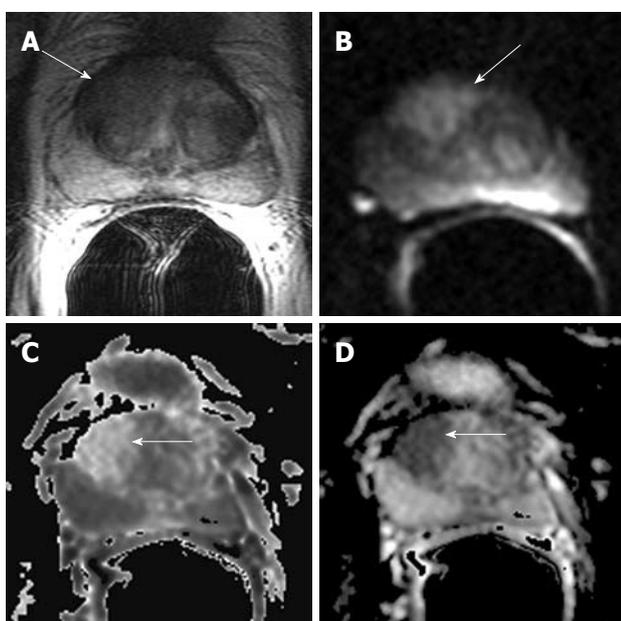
3T MR images of transitional zone tumor in a 59-year-old man with PSA level of 7.6 ng/mL and Gleason grade 3 + 4 and pT4. Transverse T2-WI (A) and transverse diffusion image (B) (b-value of 1000 s/mm²), exponential apparent diffusion coefficient (ADC) (C) and ADC obtained (D) show an infiltrating tumor (arrows) in the right transitional zone extending from base to mid-gland with anterior extraprostatic extension.
